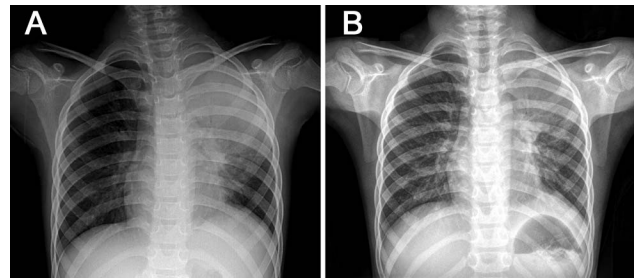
Chest radiographies of case 1 (8-y-old female). A: on admission; B: 7 d after bronchoalveolar lavage therapy.
